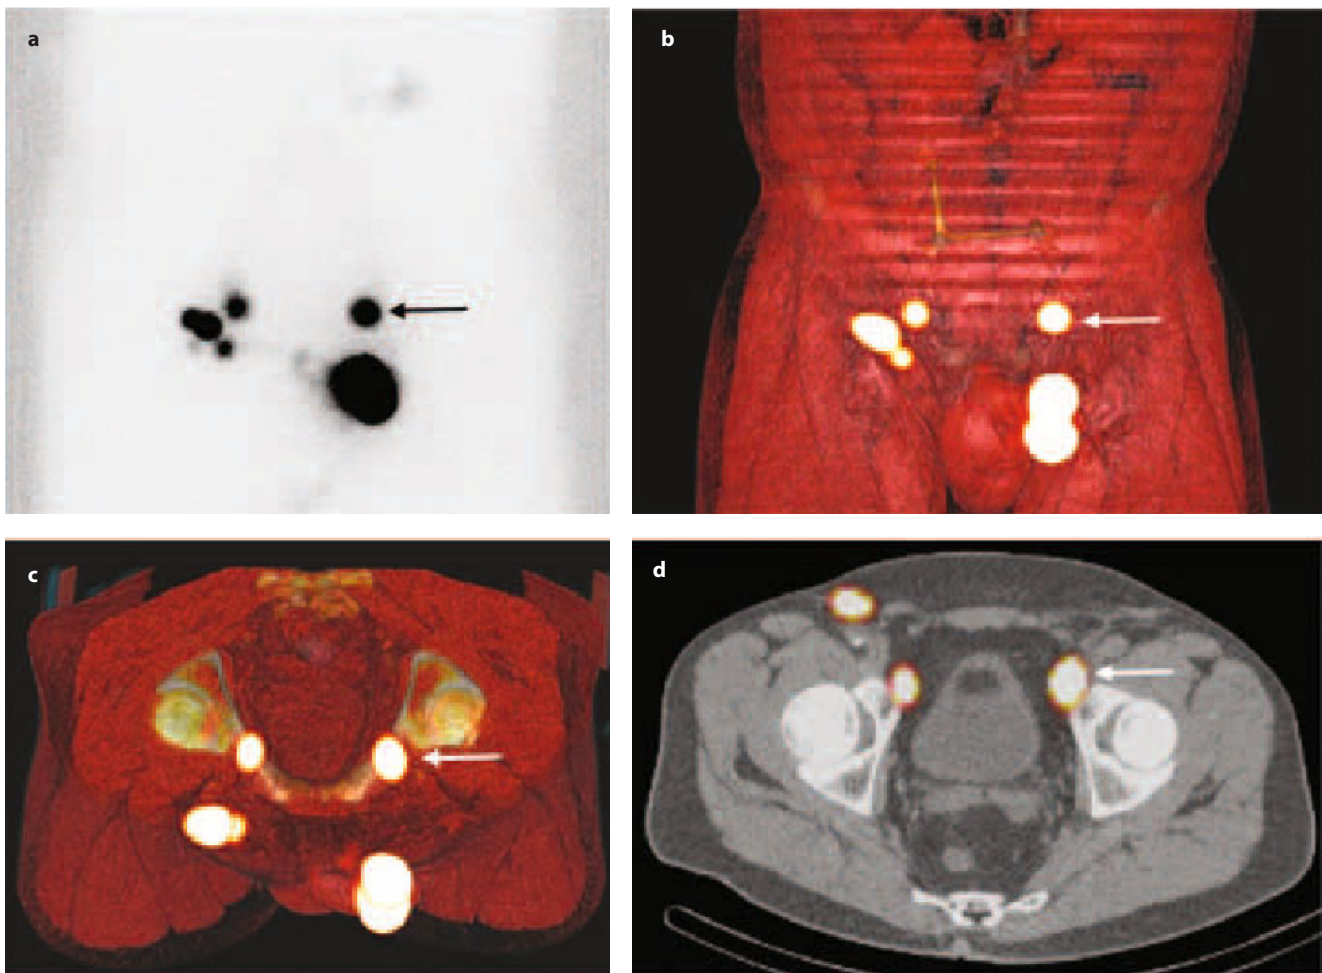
Lymphoscintigraphy in a patient with penile cancer, where the different panels correspond to different modalities of representation and the arrow indicates the same SLN on the left side, correctly assigned to a specific topographic location on the basis of tridimensional imaging. a Planar anterior image showing lymphatic drainage to both sides, seemingly to groin lymph nodes (single SLN on the left, *arrow*). b SPECT/CT with volume rendering for 3D display in the anterior view (again to seemingly groin SLNs; the *arrow* points to the same SLN indicated in panel a). c SPECT/CT with volume rendering for 3D display in a cranial view (the bottom side corresponds to the anterior side of the body) showing bilateral external iliac SLNs (the *arrow* indicates the SLN now correctly classified as external iliac SLN). d Fused axial SPECT/CT section showing anatomic location of three of the lymph nodes (two on the right and one on the left) at different depths in the pelvis (the *arrow* indicates the left external iliac SLN)
